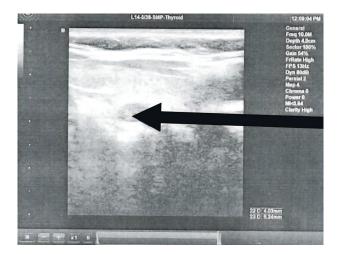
Ultrasound image showing an inferior 4.03×6.24 mm, hypoechogenic nodule, confirmed by scintigraphy as a parathyroid adenoma, marked with a black arrow.
